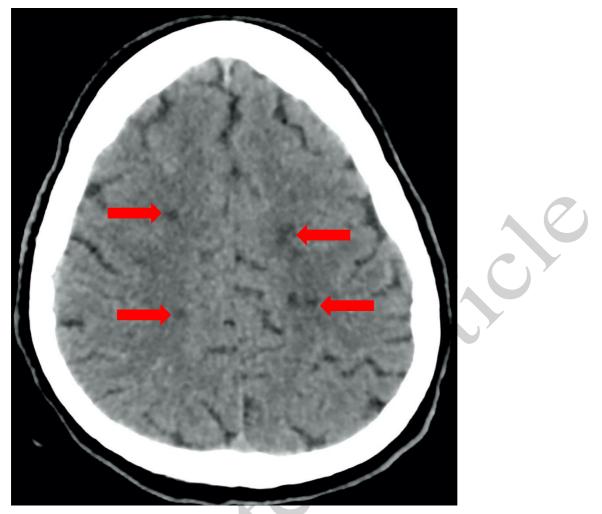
Non-Contrast enhanced Computed Tomography of the brain showing bilateral ill-defined small hypodense foci in bilateral centrum semiovale and corpus callosum (not shown) suggestive of acute infarction (Red arrows).
